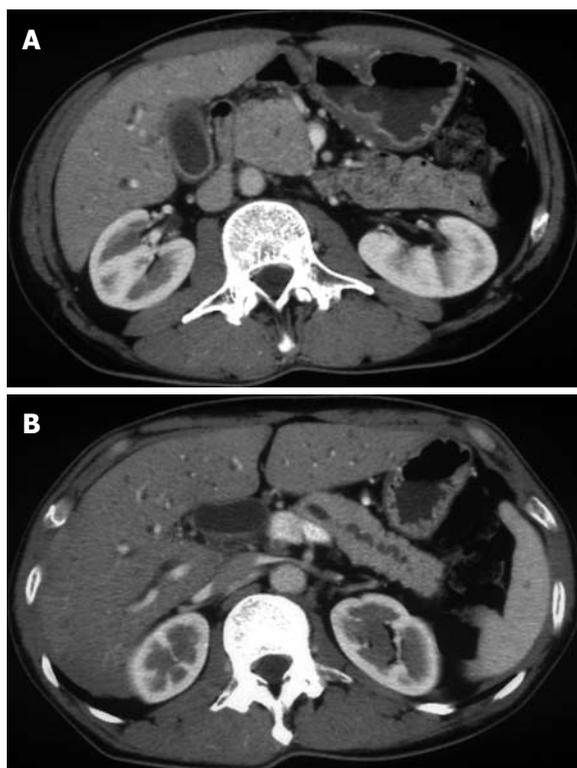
Abdominal enhanced CT imaging with contrast medium in May 2007. A: Swelling of the pancreatic head like a solid tumor was shown. B: The distal portion of the main pancreatic duct was found to be irregularly dilated; however, the pancreatic body and tail were not atrophied as seen in pancreatic cancer.
